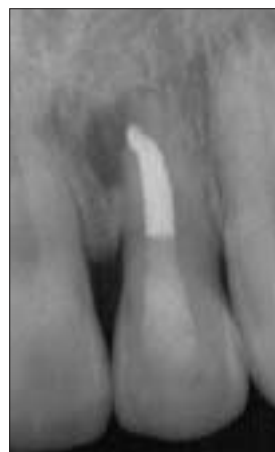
Follow-up radiograph at one year; the tooth is asymptomatic but the radiolucency has not been reduced, indicating persistence of the disease.
